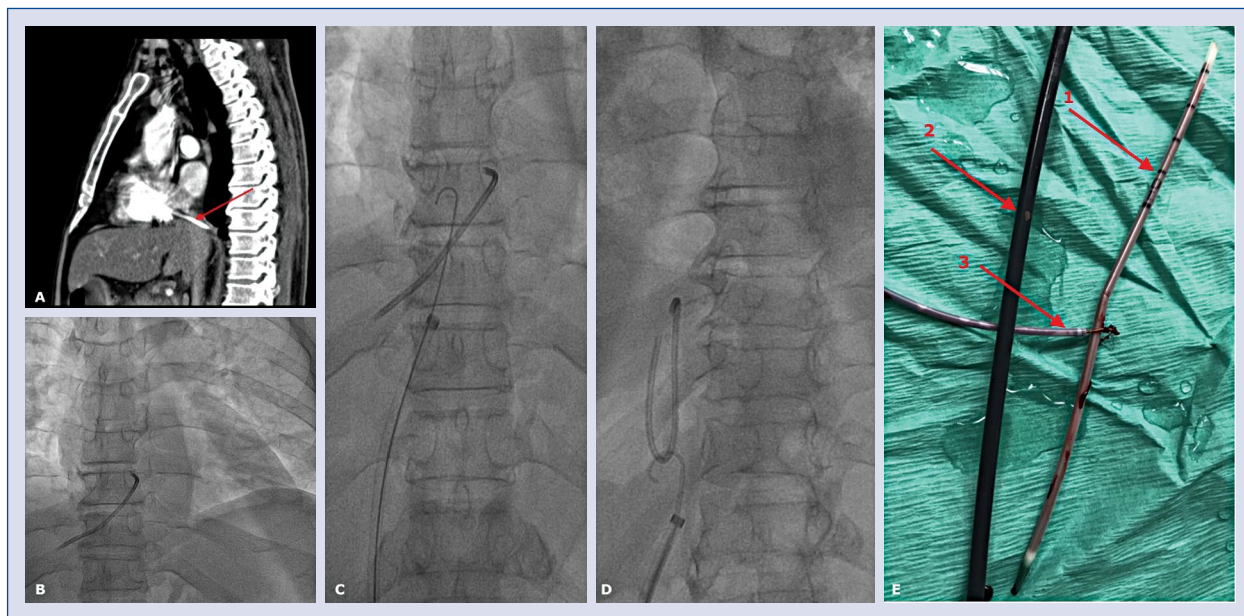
A. Computed tomography (sagittal plane) — red arrow pointing catheter in inferior vena cava (IVC); B. Chest X-ray (AP, section); a long radiopaque fragment of catheter from right heart to IVC; C. 12 F sheath inserted from femoral vein up to IVC; D. Catheter grasped by a pigtail catheter, folded and pulled into IVC; distal end inleashed; E. After procedure: removed 13 cm catheter fragment (1), trapped by Amplatz snare (3) next to 12 F sheath (2).
